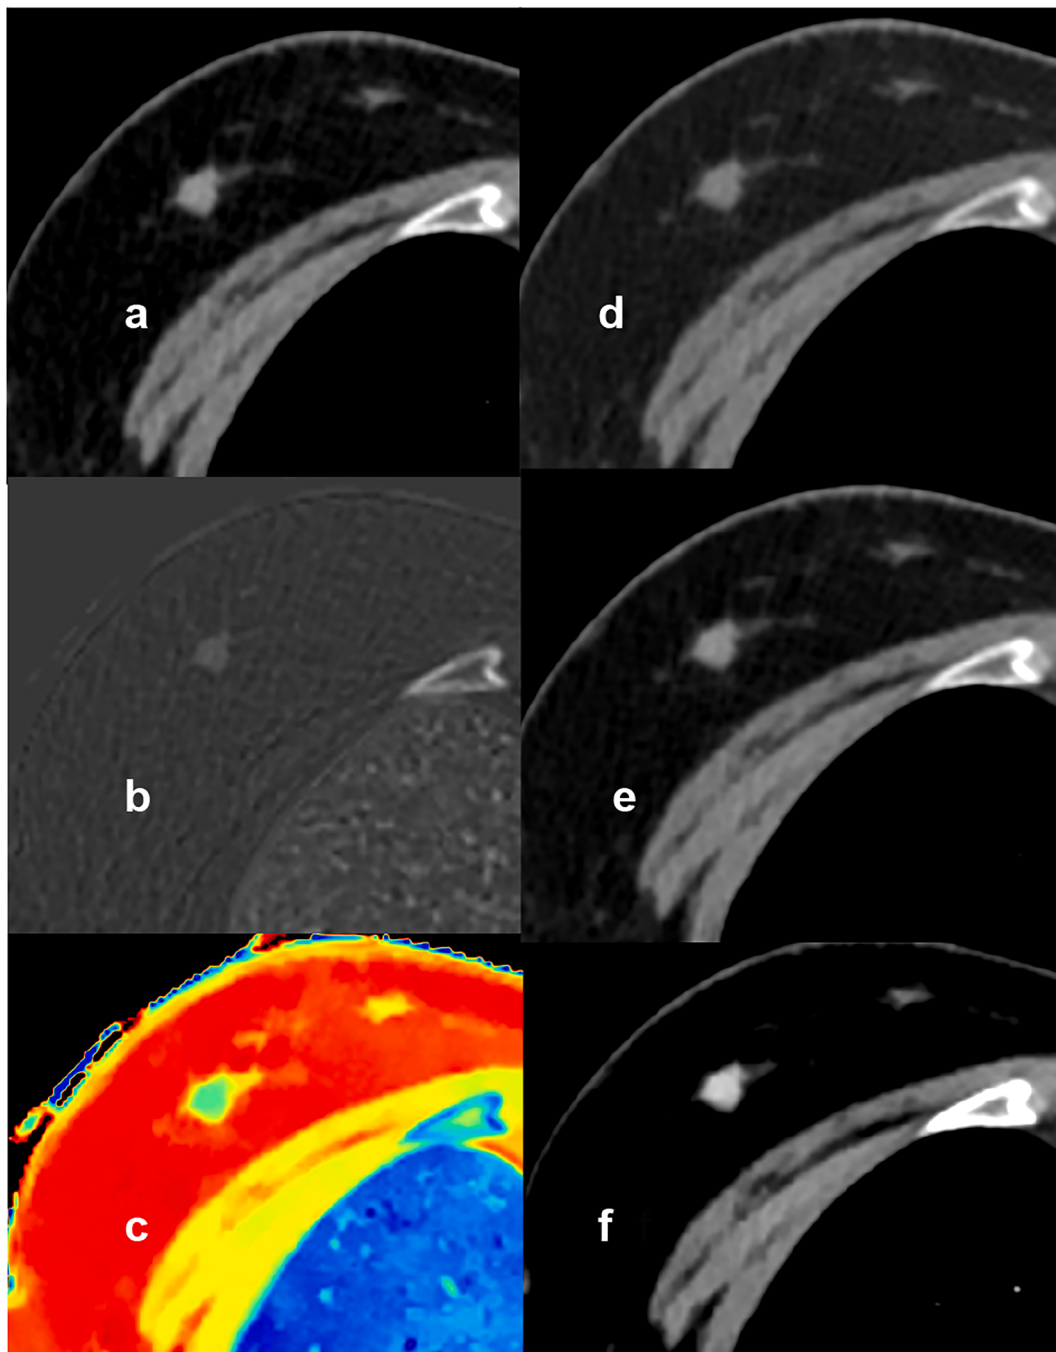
46-year-old female patient with recurrent invasive ductal breast cancer, G3, triple negative, Ki-67 90%, of 5 mm diameter on the surgical resectate. Solid tumor with irregular margins and a mean density of 83.6 HU on the conventional CT-image (a), an iodine-uptake of 1.39 mg/ml in the iodine-map (b), an elevated Z effective value of 8.10 on the Zeffective-map (c) and increasing mean densities in the virtual monoenergetic images from 57.9 HU at 100 keV (d), over 78.11 HU at 70 keV (e) to 161.8 HU at 40 keV (f).
